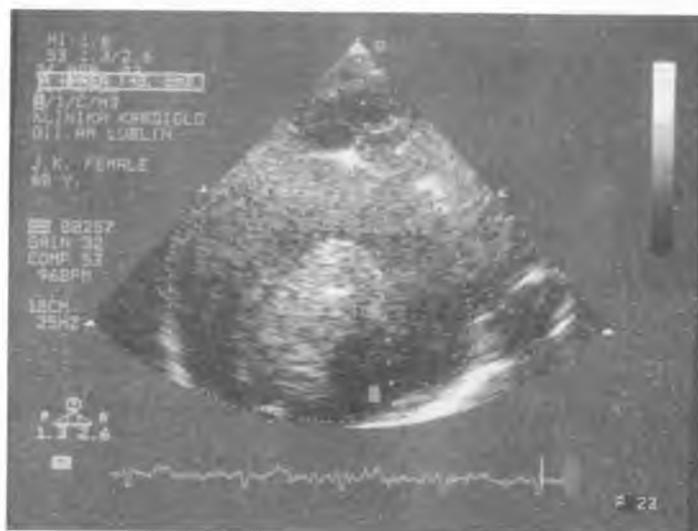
Echocardiography, modified four-chamber view: giant left atrium with big thrombus inside. Planimetric left atrial area = 143 cm² (!), left ventricle area 20 cm². Sluggish echogenic blood movement around is present
